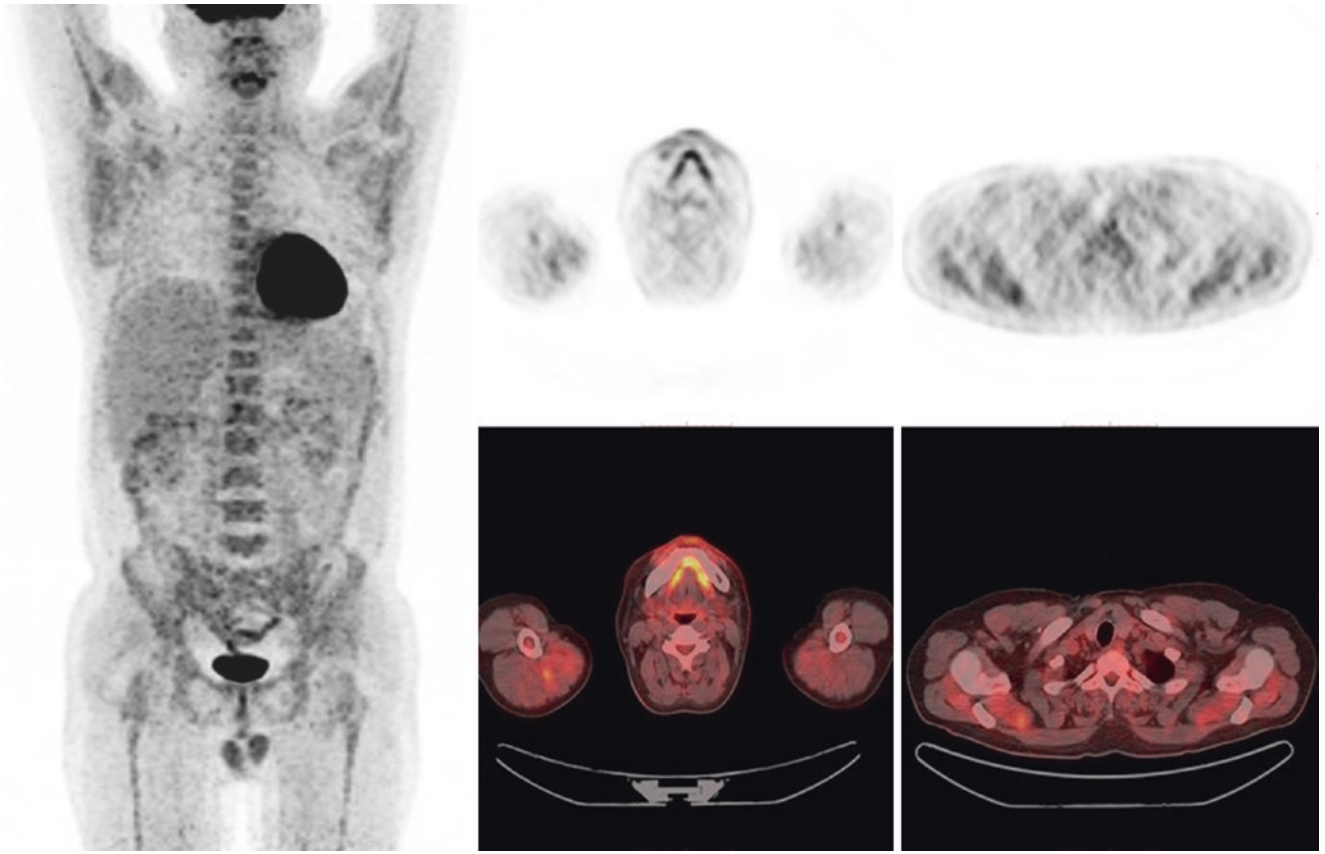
Demonstrates moderate increased FDG uptake in PET/CT images in the whole body muscle, especially the bilateral upper limb muscles. In addition, systemic bone radioactivity uptake was significantly increased
